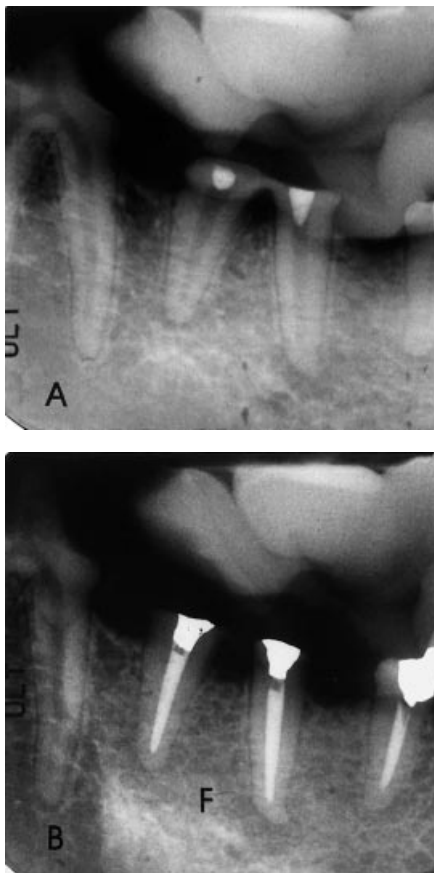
Radiographic presentation of lesions assessed as failed (F). (A) Immediate postop; (B) six-month follow-up.
